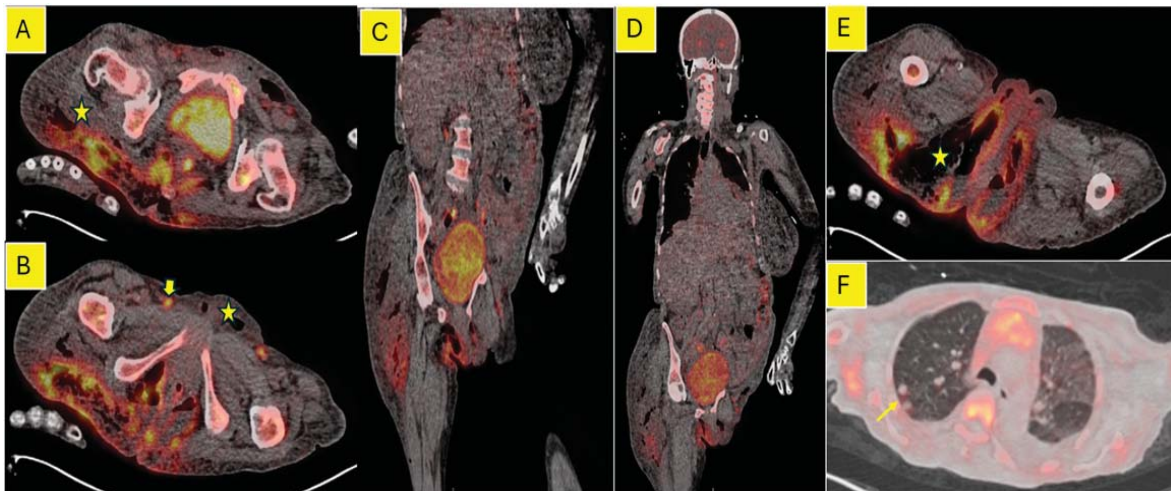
(A-F): FDG PET/CT study. A (fused axial) showing hypermetabolic Fournier's gangrene with emphysema (asterisk); B (fused axial) showing hypermetabolic subcentimeter bilateral inguinal nodes (arrow, likely reactive) and emphysema in vulva (asterisk); C & D (fused coronal at different levels) images showing hypermetabolic emphysematous area in right gluteal region and body wall edema; E (fused axial) showing hypermetabolic emphysematous process involving soft tissue planes in right gluteal and perineal regions (asterisk); F (fused axial) showing soft tissue pulmonary nodules in right upper lobe suggestive of metastasis (arrow).
